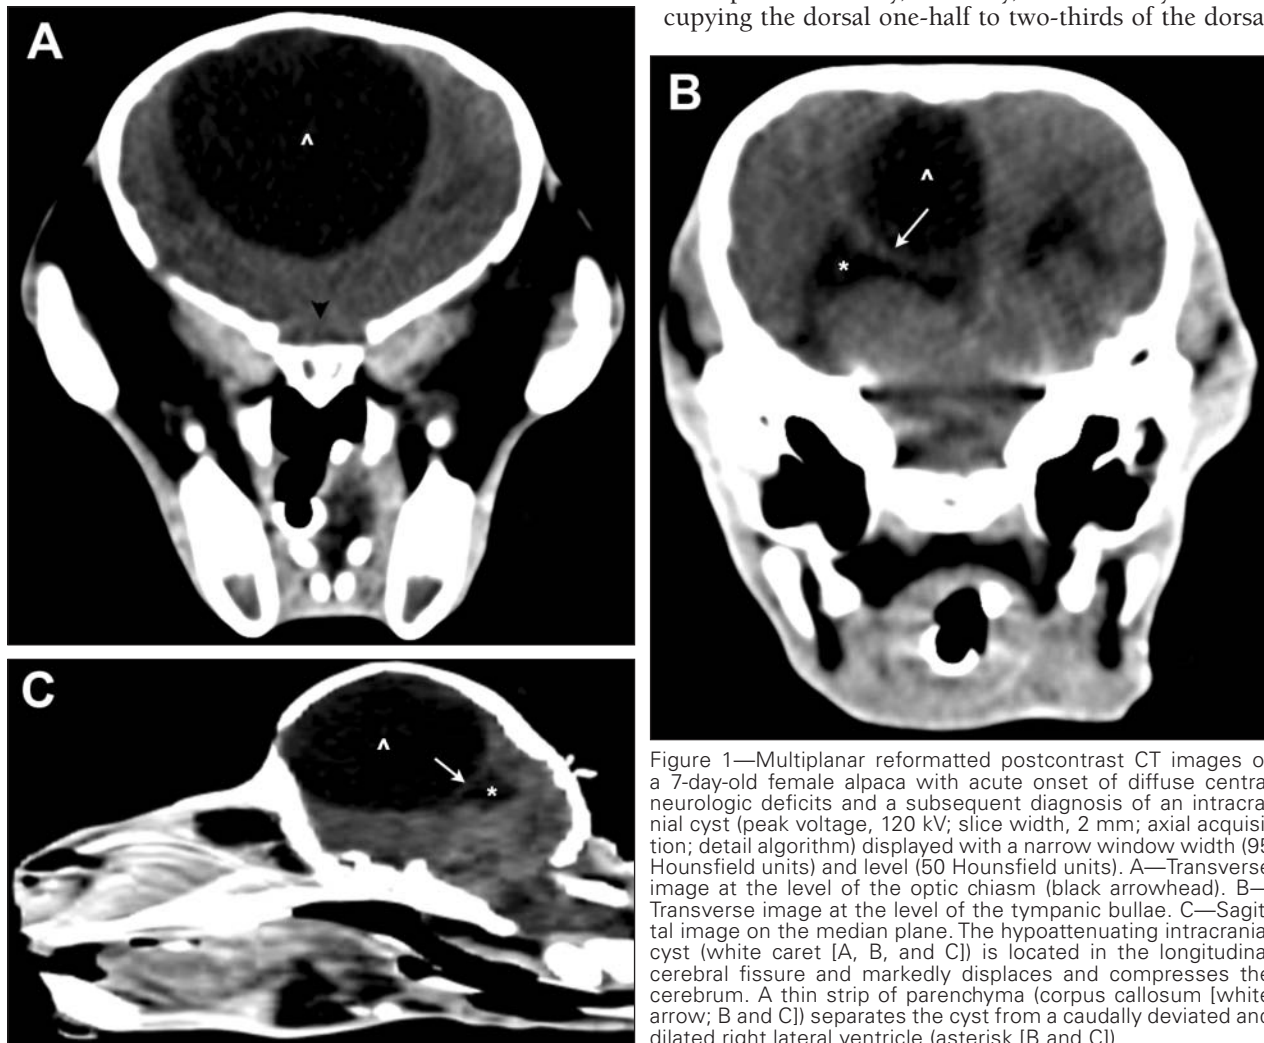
Multiplanar reformatted postcontrast CT images of a 7-day-old female alpaca with acute onset of diffuse central neurologic deficits and a subsequent diagnosis of an intracranial cyst (peak voltage, 120 kV; slice width, 2 mm; axial acquisition; detail algorithm) displayed with a narrow window width (95 Hounsfield units) and level (50 Hounsfield units). A—Transverse image at the level of the optic chiasm (black arrowhead). B—Transverse image at the level of the tympanic bullae. C—Sagittal image on the median plane. The hypoattenuating intracranial cyst (white caret [A, B, and C]) is located in the longitudinal cerebral fissure and markedly displaces and compresses the cerebrum. A thin strip of parenchyma (corpus callosum [white arrow; B and C]) separates the cyst from a caudally deviated and dilated right lateral ventricle (asterisk [B and C]).
